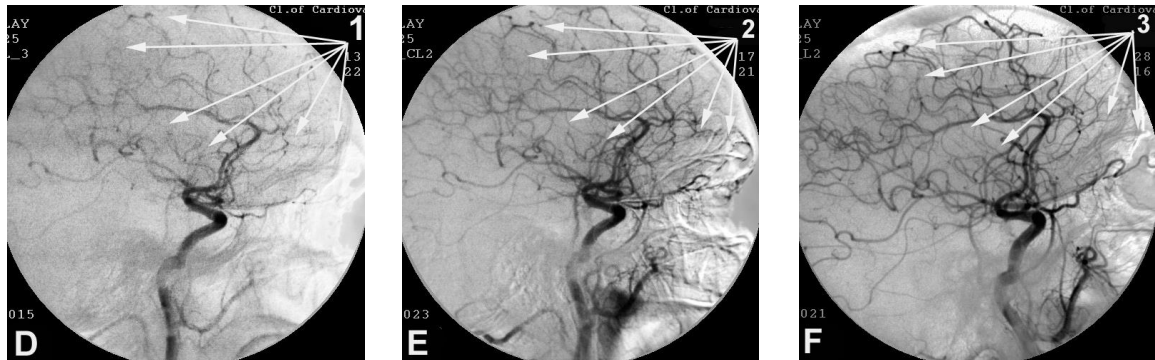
Patient T., 61 years old, male (TDR-2): CT scan of the brain and MUGA of the left internal carotid artery before and after transcatheter intracerebral laser PBMT.
